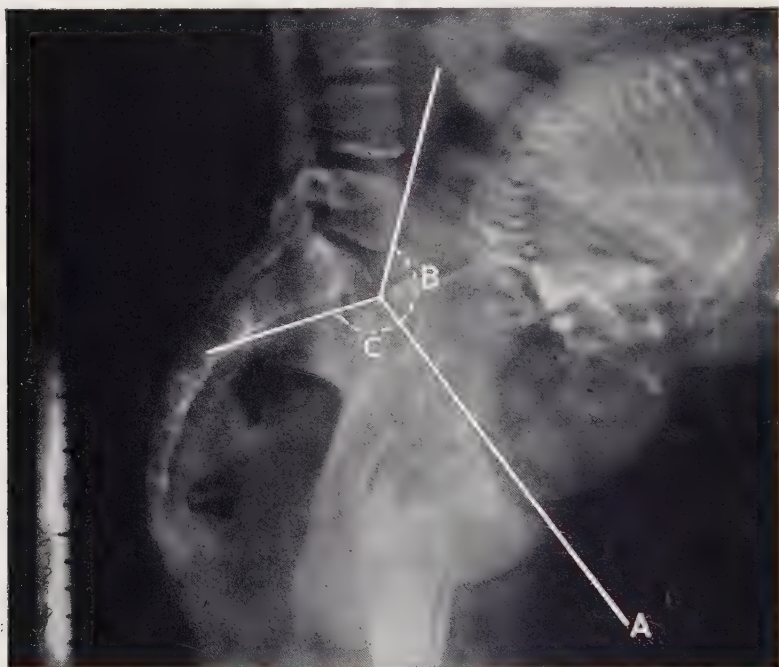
A LATERAL X-RAY OF THE PELVIS, THE FŒTUS IS IN AN OCCIPITO-POSTERIOR POSITION (Chassar Moir).
